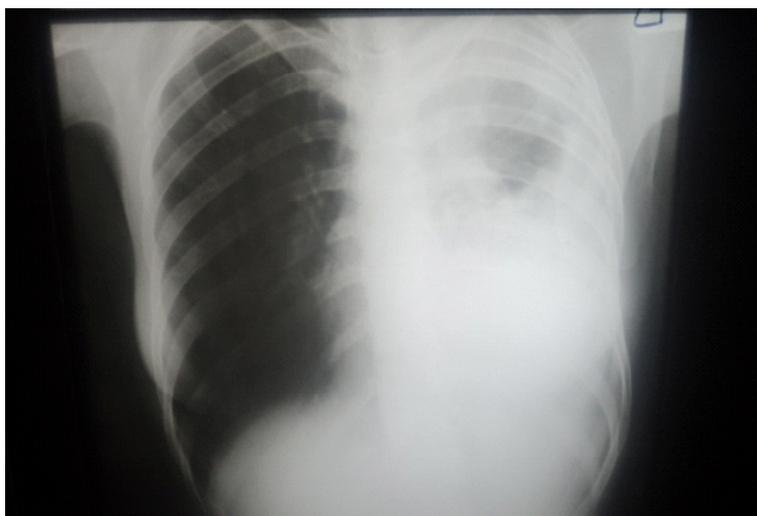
Chest X-ray showing collapse of left lung
